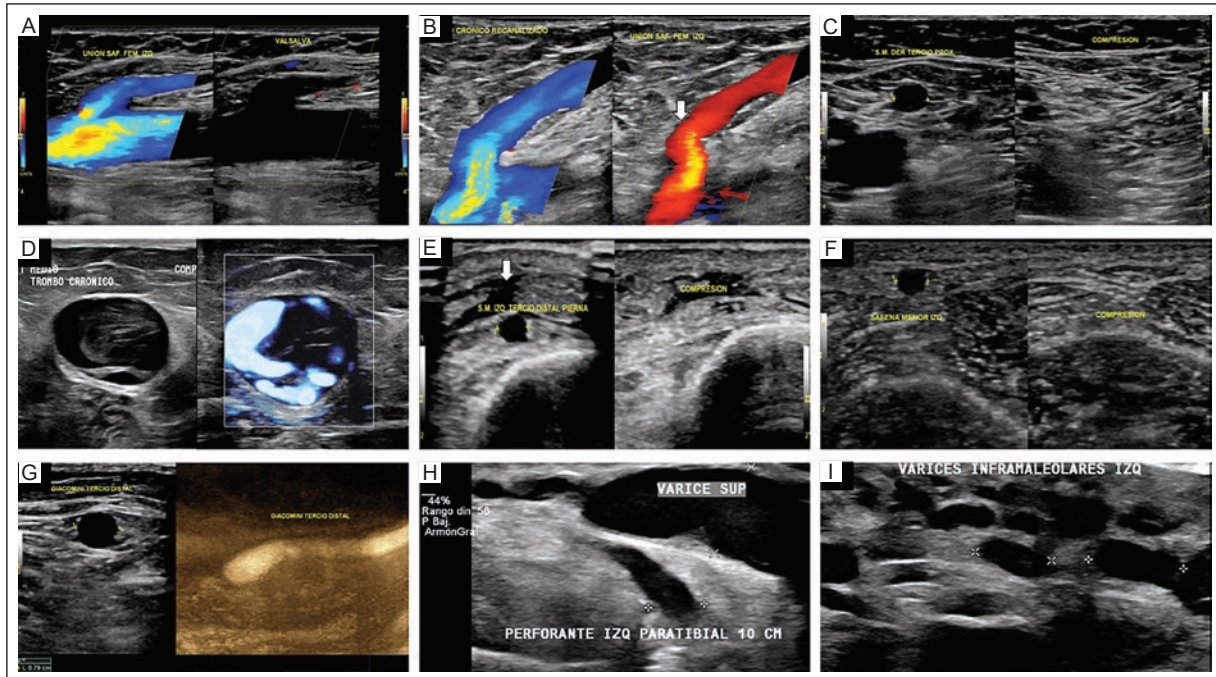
A: sagittal view, color Doppler US of the left saphenous-femoral junction, showing patency and flow direction. No reflux is observed with the Valsalva maneuver. B: sagittal view; color Doppler US of the left saphenous-femoral junction with patency and normal flow direction. Reflux is observed with the Valsalva maneuver (arrow). C: transverse view, grayscale US of the right great saphenous vein in the proximal third of the thigh with a diameter of 7.2 mm (not shown) and complete compressibility maneuver. D: transverse view, grayscale and color Doppler US of the left great saphenous vein in the middle third of the thigh with echogenic material corresponding to a chronic thrombus with partial recanalization <50%. E: transverse view, grayscale and color Doppler US of the left great saphenous vein in the distal third of the leg with a diameter of 4.3 mm (not shown) and complete compression maneuver. There is also mild edema of the subcutaneous tissue (arrow). F: transverse view, grayscale US of the left lesser saphenous vein with a diameter of 4 mm (not shown) in the middle third with complete compression maneuver. G: transverse view, US grayscale and sagittal view in B-Flow showing a variant of Giacomin's vein with a 7.9-mm (not shown) diameter and normal patency in B-Flow US. H: transverse view, grayscale US showing the left paratibial perforating vein with a diameter of 4.57 mm, located 10 cm from the inferior border of the lateral malleolus. It drains into a dilated superficial varicose vein (8.14 mm, not shown). I: transverse view, grayscale US of the left inframalleolar variceal bundle with 8- and 9-mm (not shown) diameters.
